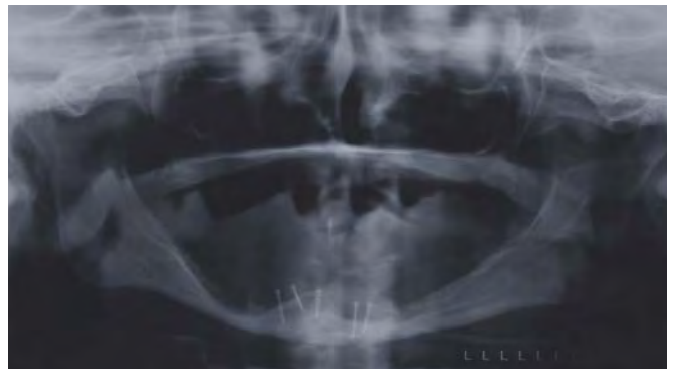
Postoperative radiograph with graft in situ in anterior mandible.
